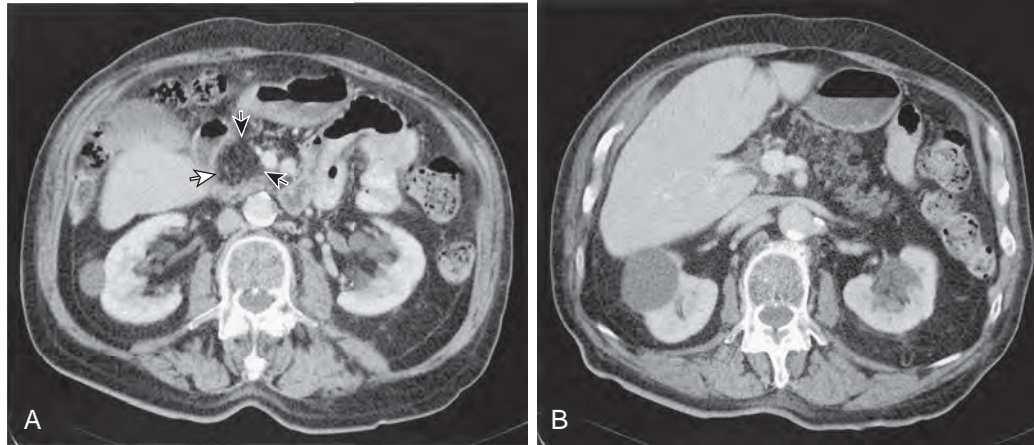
Fatty infiltration of the pancreas. A. CT of the pancreatic head reveals a large area of fatty infiltration in the head of the pancreas (arrows). A portion of the uncinate process is spared from fat. Notice lack of any mass effect on the adjacent superior mesenteric vein. B. Fatty infiltration is also present in the pancreatic body. The tail is spared.
